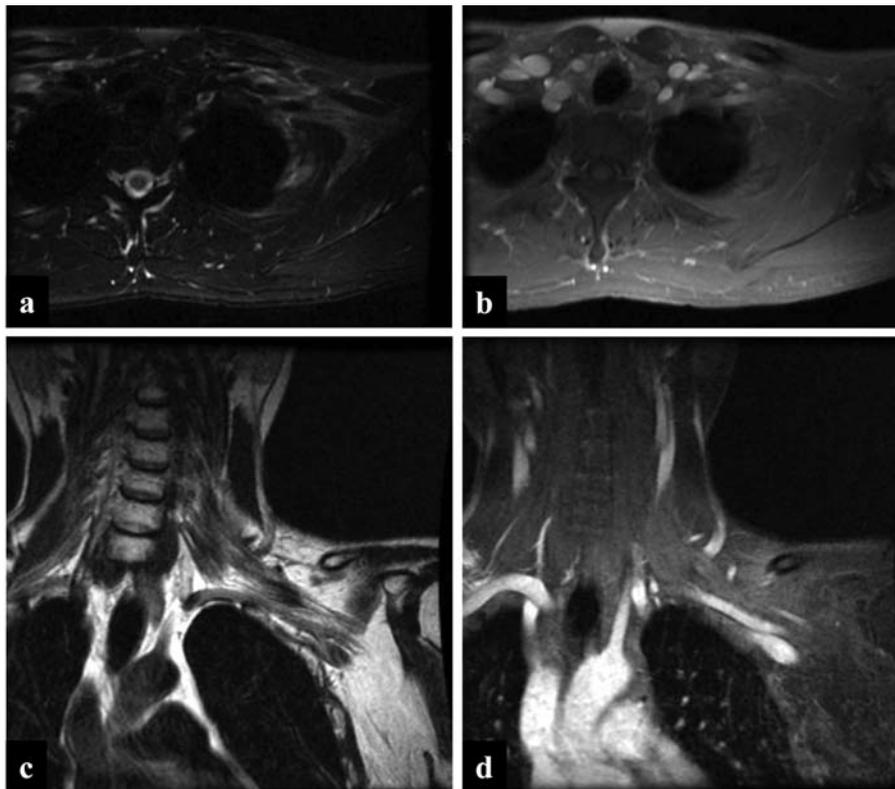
The tumor disappeared in magnetic resonance imaging after the chemotherapy. a: Axial T2-weighted image shows the tumor at the brachial plexus. b: Gadolinium-enhanced axial image shows ring enhancement. c: Coronal T2-weighted image shows the tumor in the left brachial plexus. d: Gadolinium-enhanced coronal image shows ring enhancement.
